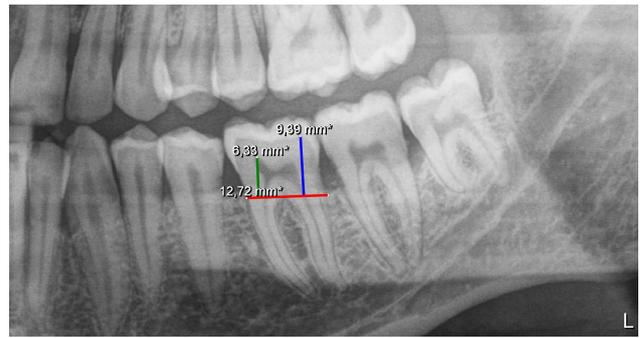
Mandibular first molar measurements on panoramic radiography. Crown height was measured from furcation line to the highest dentin point (green line). Pulp horn was measured from the furcation line (red line) to the tip of the pulp horn (blue line).
